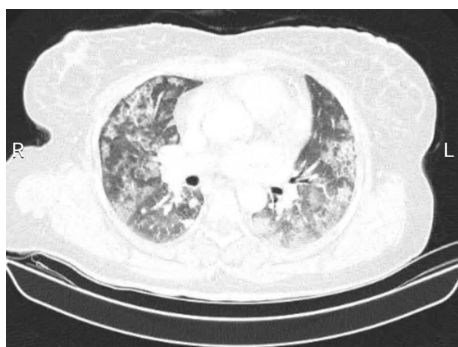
Chest HRCT of the index case showing bilateral diffuse ground-glass opacifications creating the 'crazy-paving' pattern.
